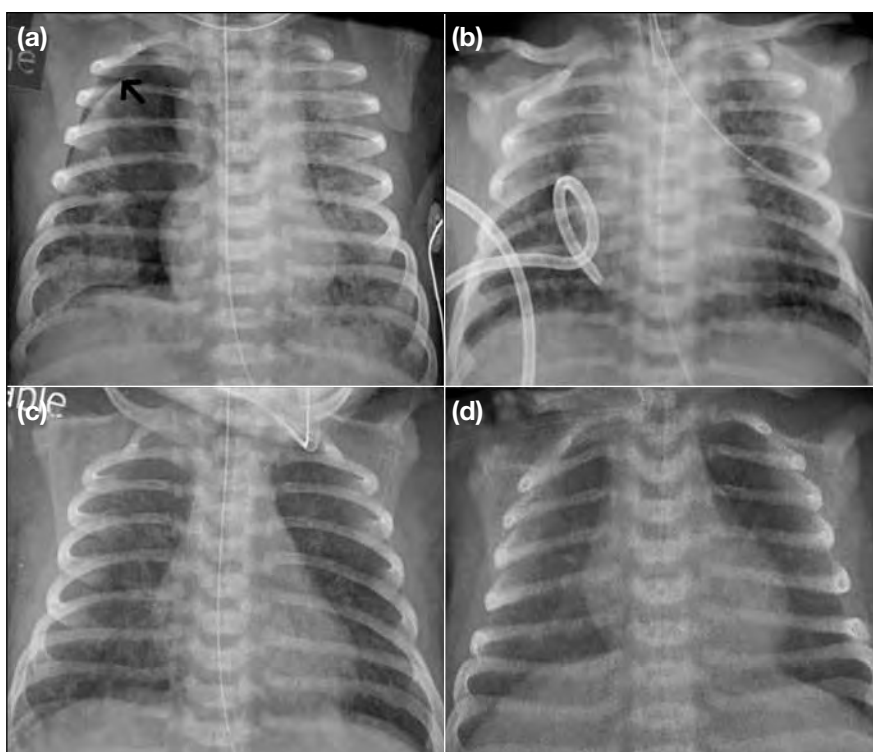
Pneumothorax complicating meconium aspiration syndrome. A 40+6 weeks baby girl delivered by vacuum extraction delivery for non-reassuring fetal status, presented with respiratory distress. (a) Chest X-ray on day 0 showing hyperinflation and patchy, coarse irregular opacities, typical of meconium aspiration syndrome. It was complicated by a right pneumothorax (arrow). (b) Chest X-ray on day 1 showing interval insertion of right chest drain with resolution of right pneumothorax. (c, d) Chest X-ray on day 4 and 6 showing progressive interval radiographic improvement of meconium aspiration syndrome.
